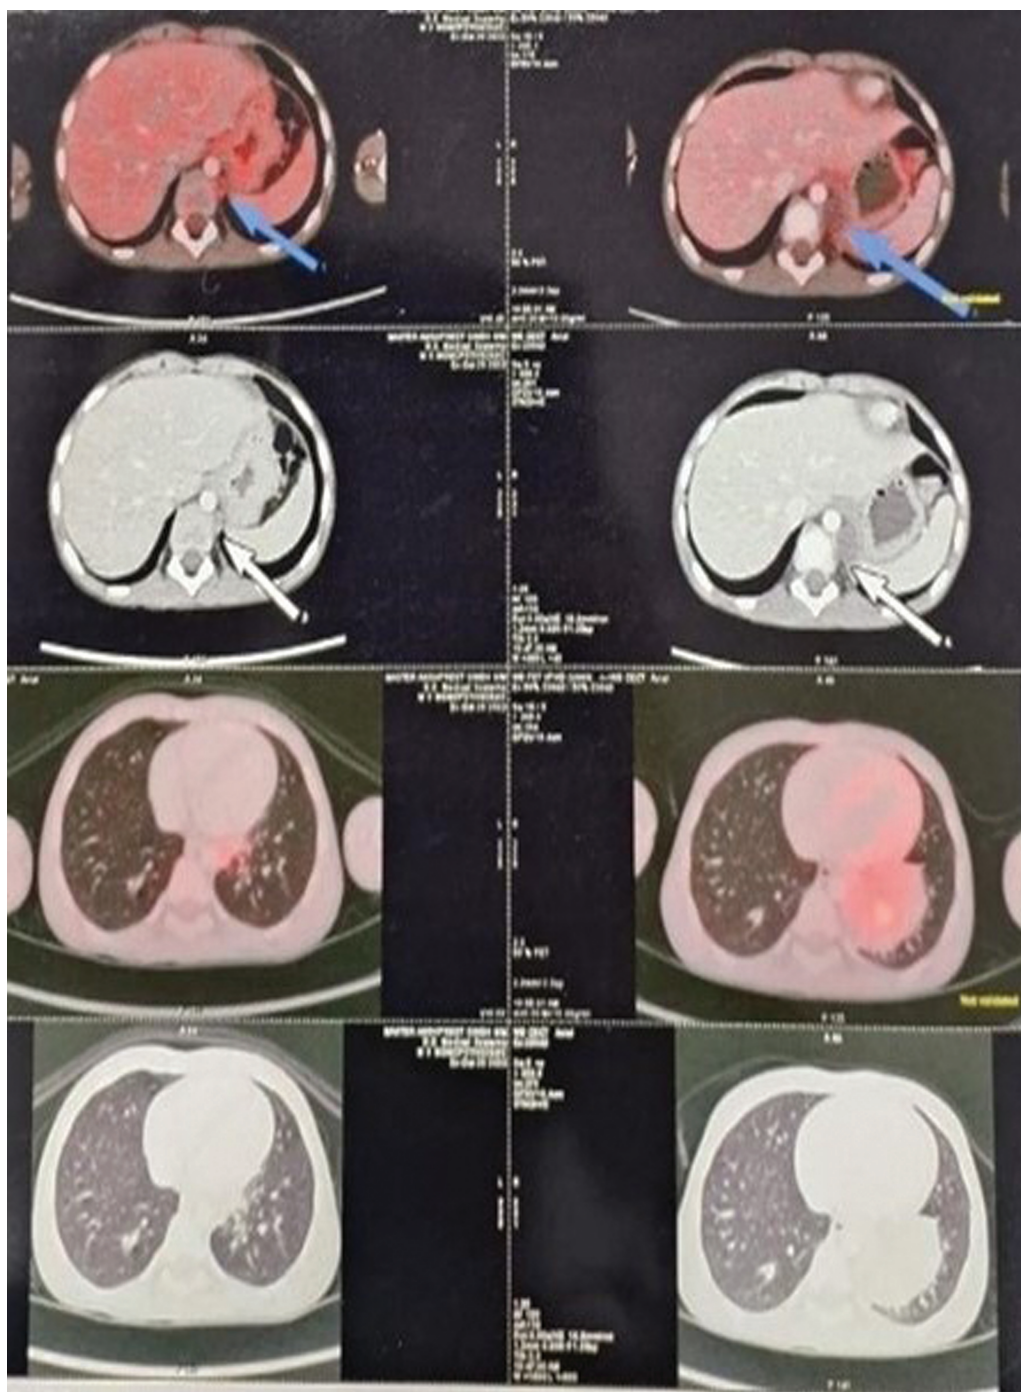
Positron emission tomography computed tomography scan showing soft tissue mass in the lower left lung lobe.
